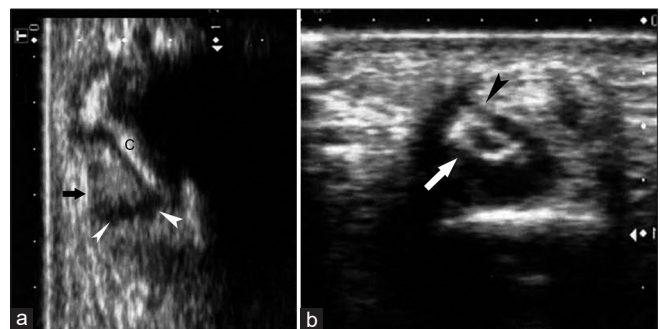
(a) Longitudinal ultrasound image shows a lobular echogenic mass (arrow) with an outer echolucent border (arrowheads) that is superficial relative to the cortex, (c) of the phalanx, and (b) transverse ultrasound image depicts the corticated mass (arrow) arising directly from the bony cortex of the phalanx (arrowhead)
